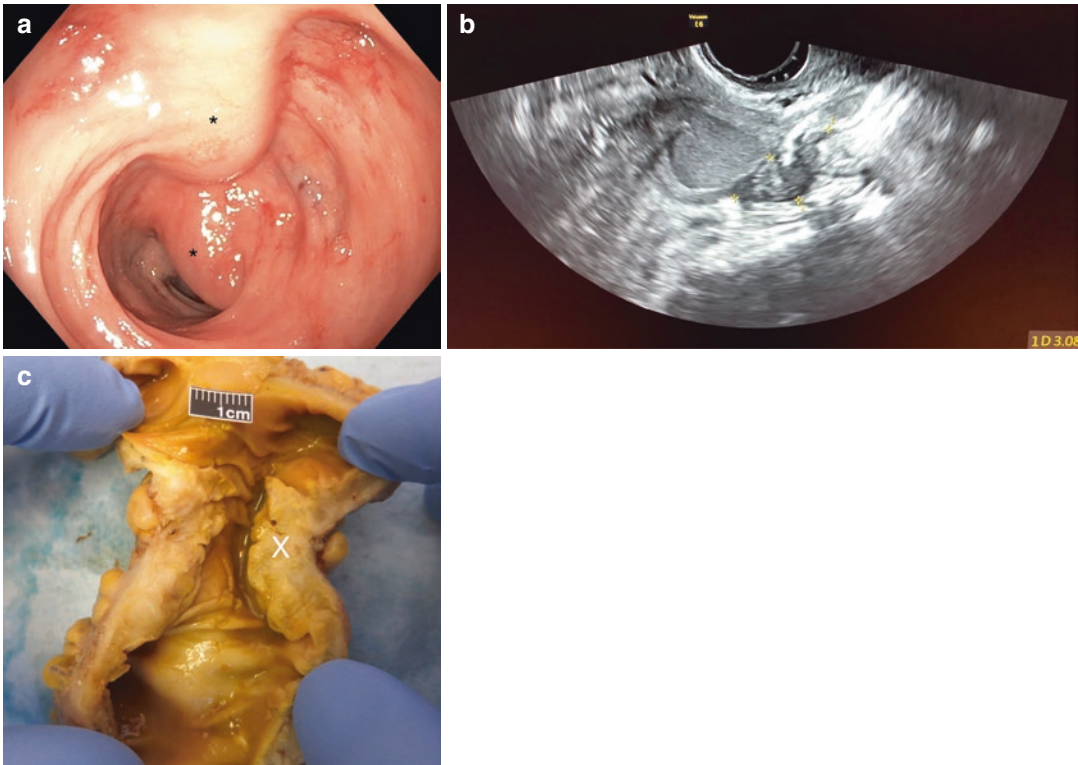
(a) Intraoperative colonoscopy is suggestive of a mass effect but not diagnostic of endometriosis (*). (b) Transvaginal expert-guided ultrasound completed preoperatively identified a rectal nodule measuring 3 × 1.4cm to aid in surgical planning (Image Courtesy of Dr. V. Della
